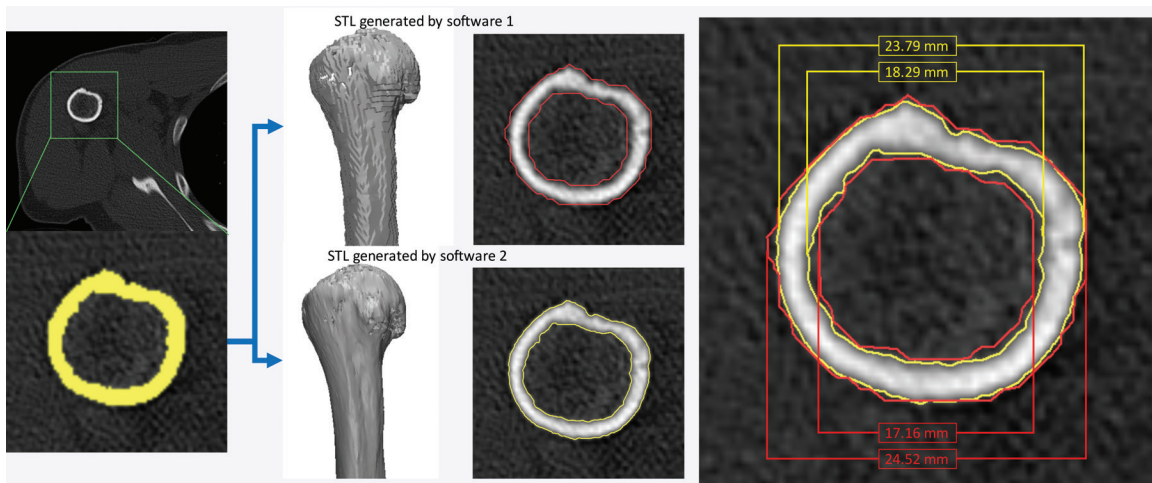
STL model generation algorithms provided in two software products (Mimics 18.0 and OsiriX [Pixmeo SARL, Bernex, Switzerland]). With both software products, axial CT images were loaded and identically segmented (yellow, lower left image) by using an attenuation threshold of 226 HU. The resulting STL models generated by using the default settings for each software differed by 0.73 mm for the external bone surface measurement and by 1.13 mm for the internal surface measurement.
